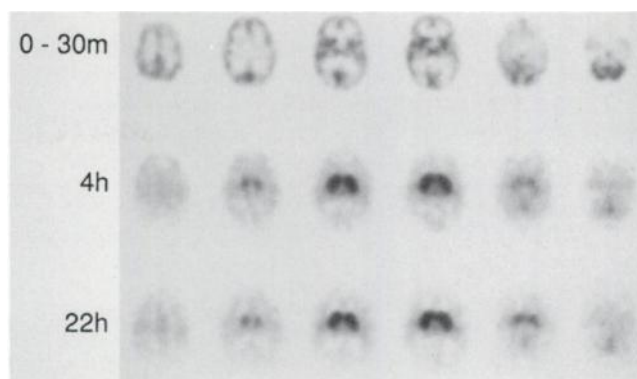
SPECT images of the human brain with respect to time after intravenous IBVM injection. The pattern of activity distribution resembles relative perfusion in the earliest images, then progressively striatal concentration dominates. At 22 hr after injection, the relative distribution of count density and IBVM binding site density index are similar. (Imaging duration: top row 20 min; mid row 30 min; bottom row 60 min.)
